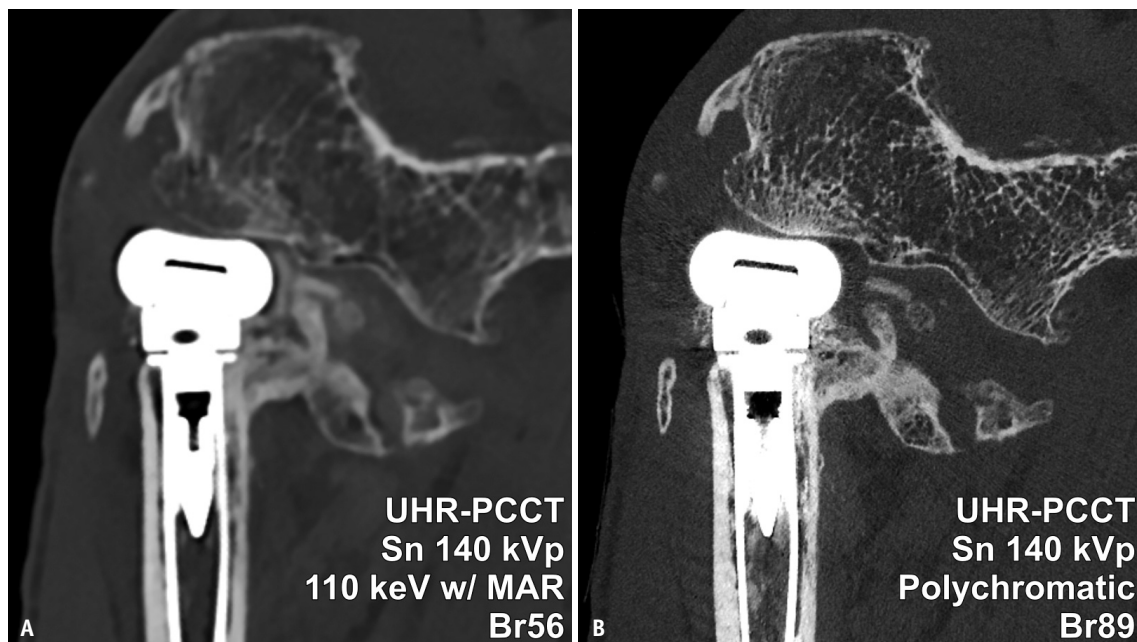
UHR-PCCT elbow scan with tin prefiltration at 140 kVp in a 66-year-old female after radial head replacement. A, B: Whereas the combination of virtual monoenergetic imaging at 110 keV and MAR postprocessing allows for superior artifact reduction (A), the limited reconstruction sharpness hampers diagnostic assessability. Meanwhile, the use of an ultra-sharp bone kernel for polychromatic data facilitates better visualization of osseous tissue albeit at the cost of increased artifact intensity at the bone-metal interface (B). UHR = ultra-high-resolution, PCCT = photon-counting computed tomography, MAR = metal artifact reduction
